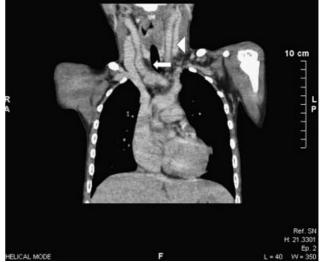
Initial chest and cervical computed tomography scan (prior to treatment with biological agent): Arrow shows concentric wall thickening of the brachiocephalic artery. Arrowhead shows ectasia of the left common carotid artery.
